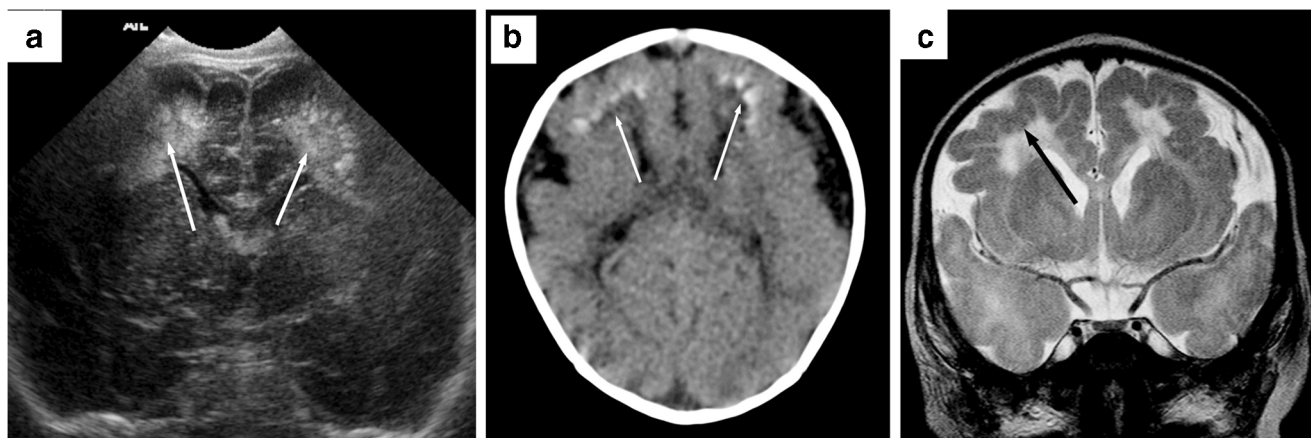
Sodium channelopathy *SCN3A* in a 2-month-old boy with apnea and seizures. a Coronal neurosonography image shows the subcortical flame-shaped marked hyperechogenicity in both frontal lobes (*arrows*). b Axial CT image shows the abnormal appearance of the brain, with thickened cortex bilaterally, undersulcation and underopercularization
